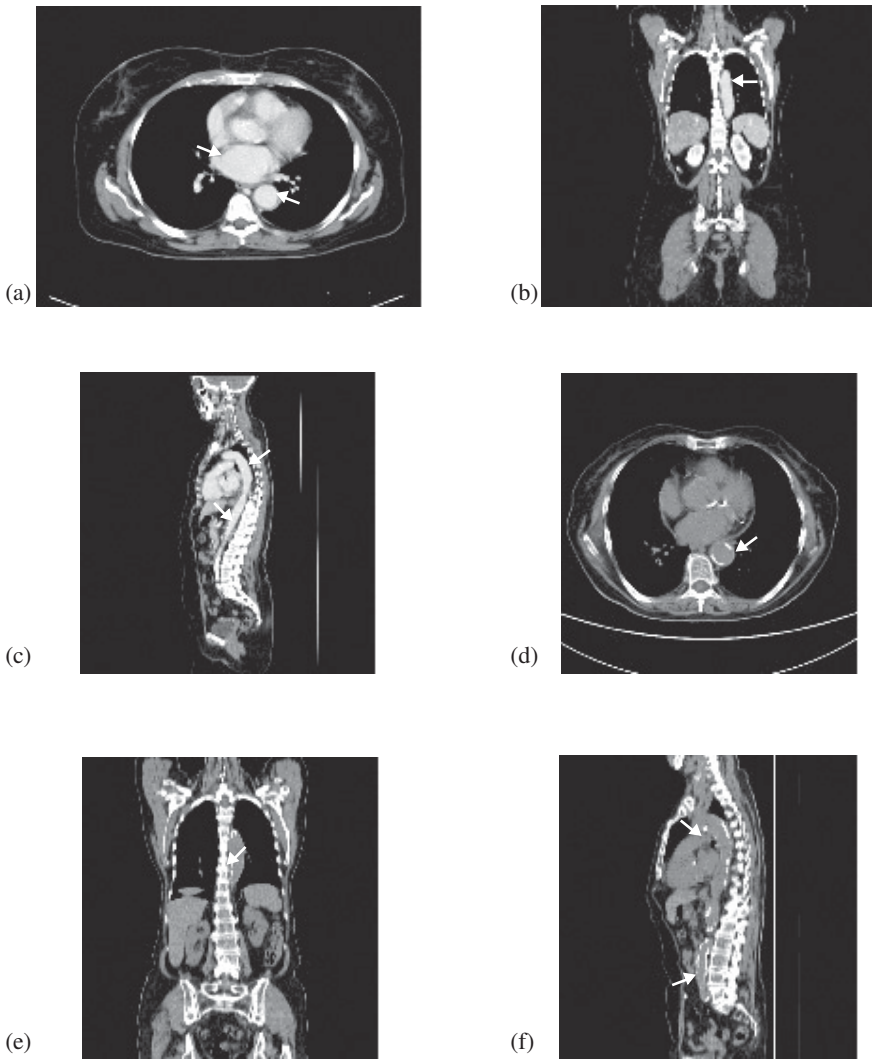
(a,b,c): Three-dimensional MultiPlanar Reconstructed (MPR) Computed Tomography images in axial, coronal and sagittal views. Images were acquired using intravenous contrast administration as in Protocol A. There is clear demarcation of contrast in the blood vessels (thick arrow). There is no intensity difference between the wall and the lumen of the aorta. Portions of the wall of the great vessels are irregular and thickened.
